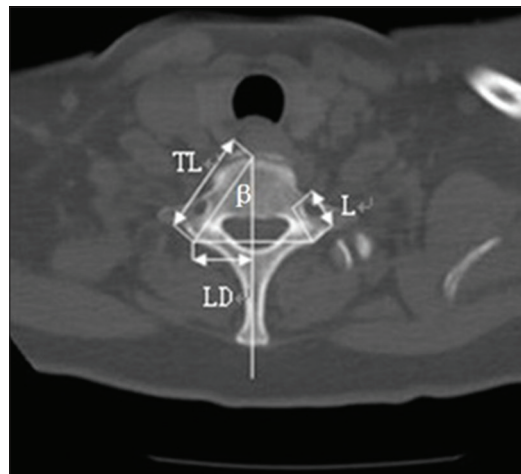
CT scan axial image showing measurement of the C7 and pedicle associated diameters and angle
